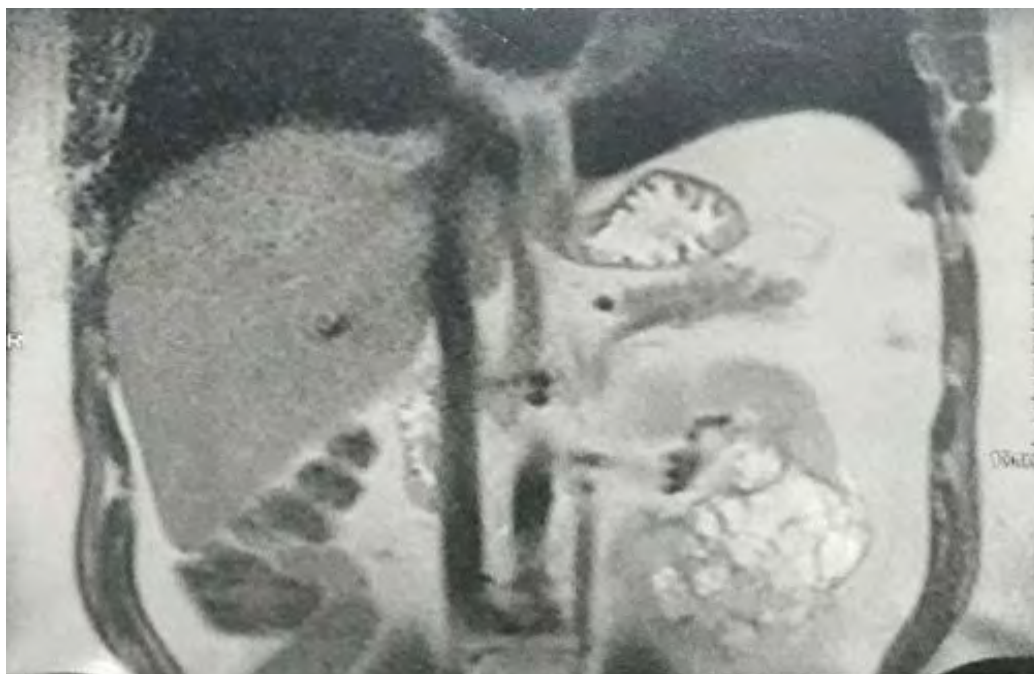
Preoperative magnetic resonance imaging showed a 12-cm left renal mass.
